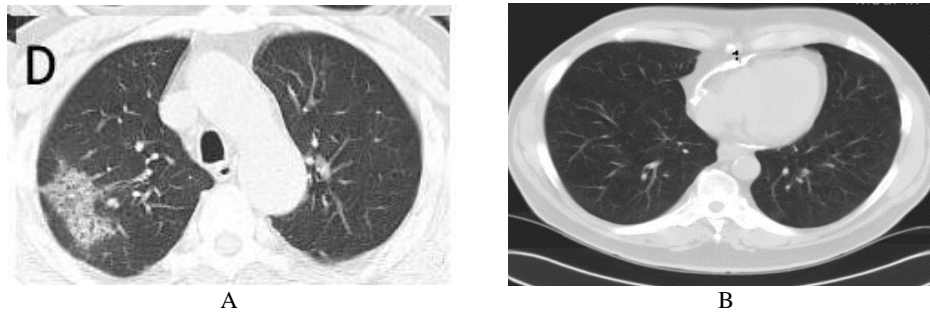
Example of COVID-19 and Normal CT images.
